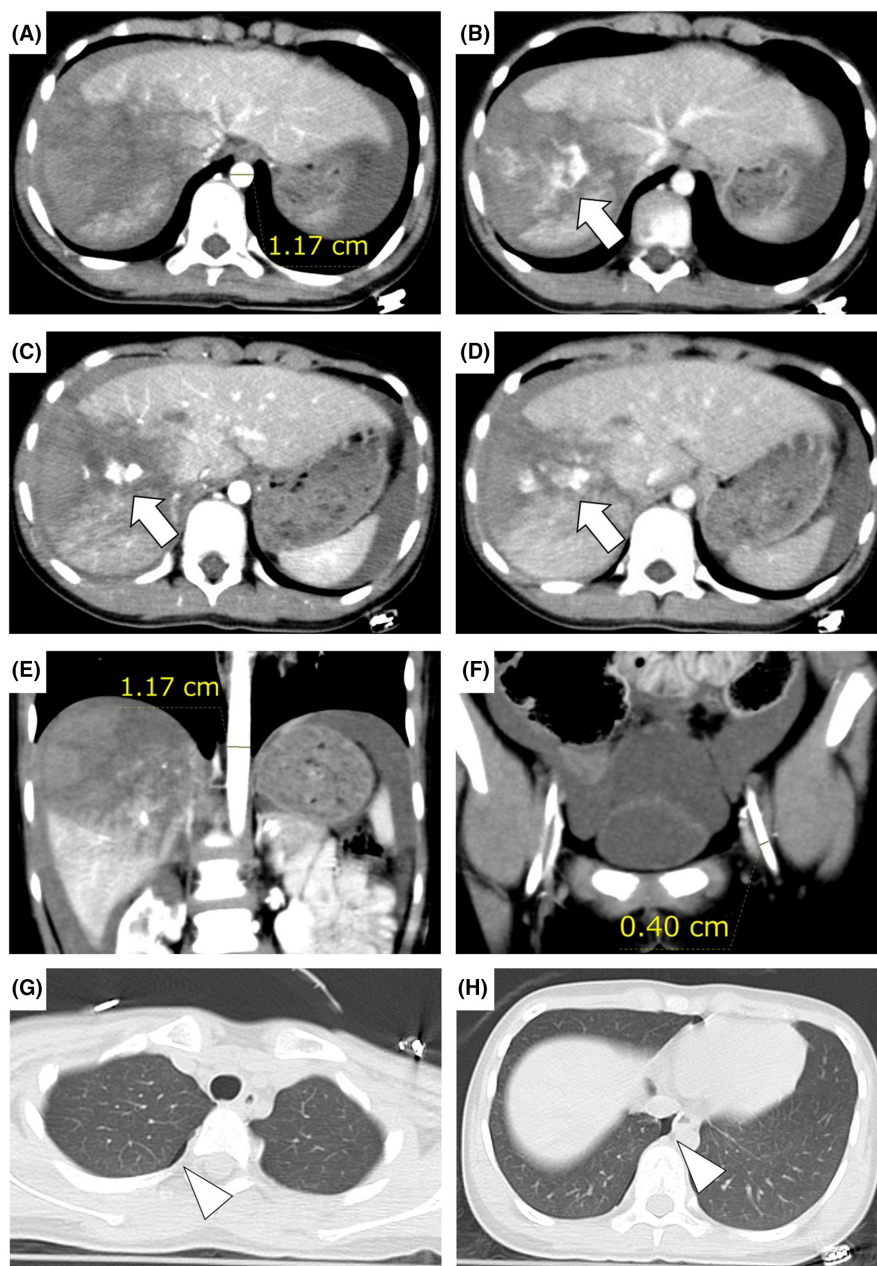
A contrast-enhanced computed tomography scan at the local hospital. (A, C) Arterial phase axial images. (B, D) Venous phase axial images. Computed tomography images revealed the massive contrast extravasation in the liver from the arterial phase to the equilibrium phase (white arrows). (E, F) Arterial phase coronal images. Computed tomography images show the thoracic descending aortic and left common femoral aortic diameters. (G, H) Chest computed tomography images show minor right pneumothorax (white arrowheads).
